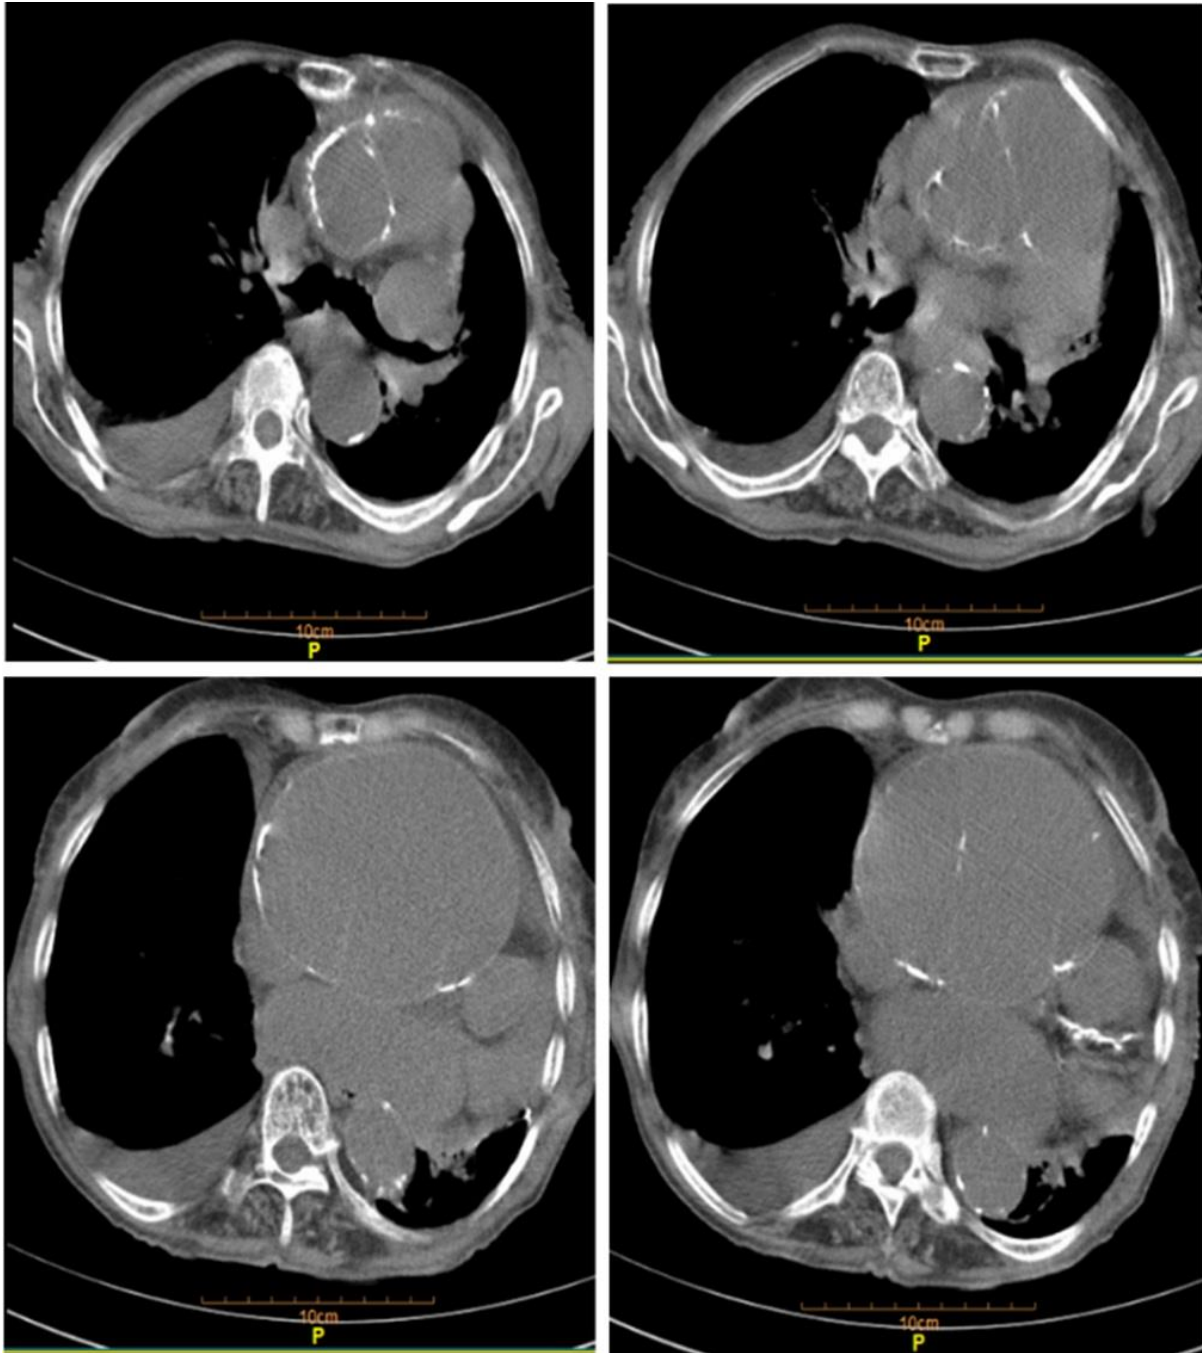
Computed tomography angiography of the aorta shows a severely dilated aorta, accompanied by a dissection flap.
